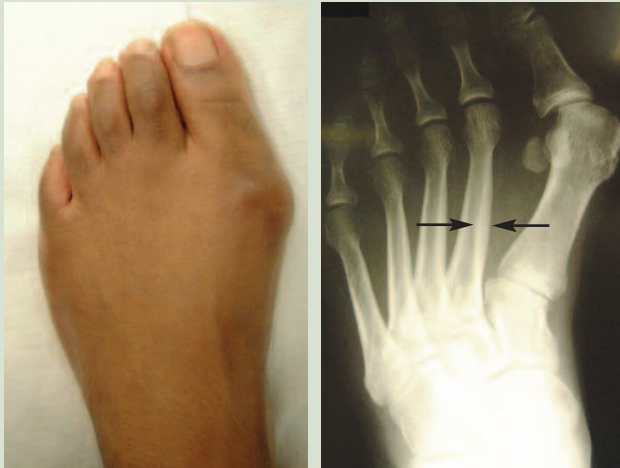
(above left). Marked bilateral hallux valgus of the left foot. Figure 1b (above right). Weightbearing AP radiograph of the foot. Cortical hypertrophy of the second ray indicates mechanical overload (arrows).
